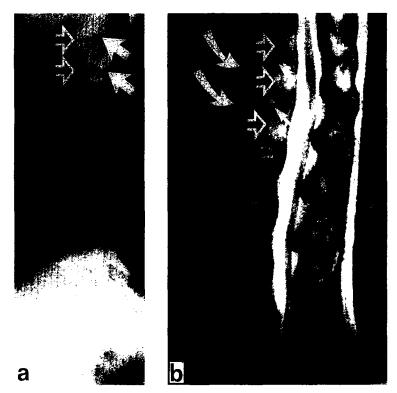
Case 2. (a) Vertebral X-ray demonstrates moderate destruction of Th12-L1, with narrowing of the intervertebral discs (open arrows) and destruction of the endplates (solid arrows). (b) Sagittal T2-weighted MR image shows destruction of the endplates (solid arrows), increased signal intensity of Th12, L1 and L2 (open arrows) and prevertebral soft tissue swelling (curved arrows).
